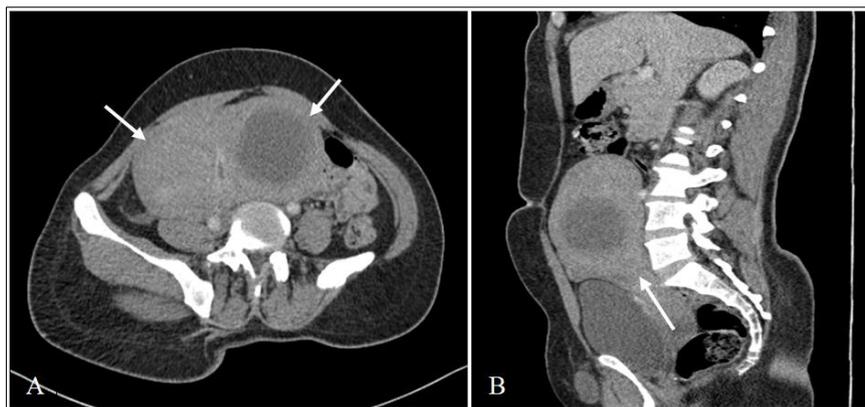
Axial (A) and sagittal (B) slices of abdominopelvic CT: Several lesional formations related to uterine myomas
